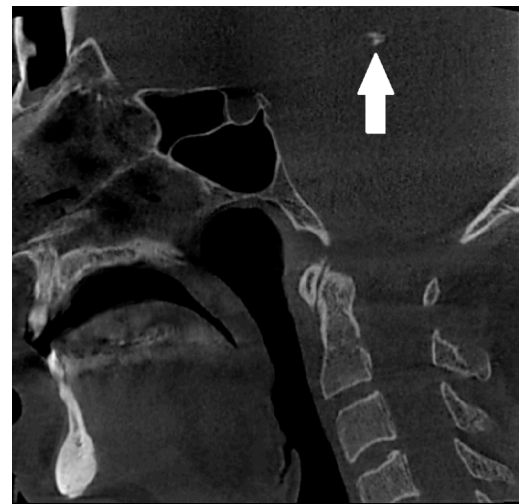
Mid-sagittal CBCT image of a pineal gland calcification (arrow).
